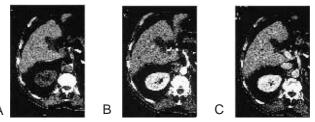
Follow-up CT scan achieved 7 months after initial CT. A, Unenhanced CT scan shows a 5 mm low attenuating lesion. B and C, Respectively arterial and portal phase CT scan obtained at the same level as A shows absence of parenchymal enhancement.
